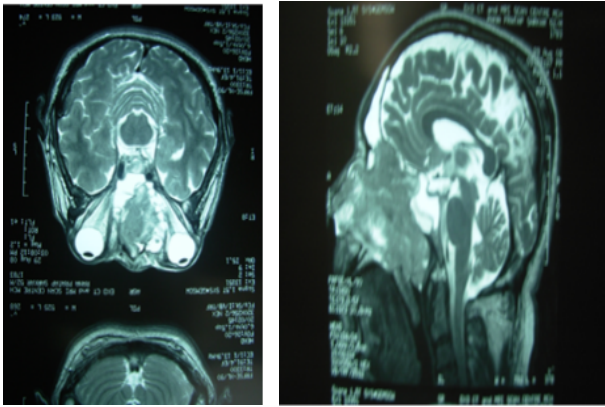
CT scan & MRI of patient no. 5.
